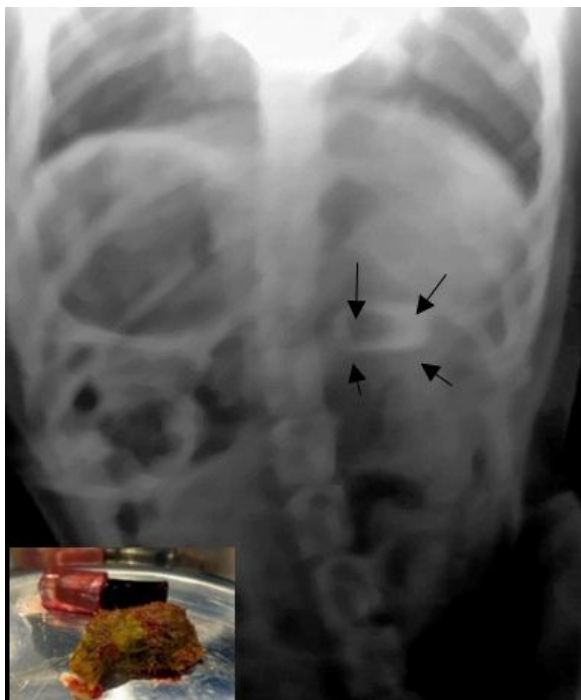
The radiograph of abdomen (ventro-dorsal view) showed presence of radio-opaque foreign body at pyloric end of syomach. No marked gaseous distension in and around the foreign material was observed
